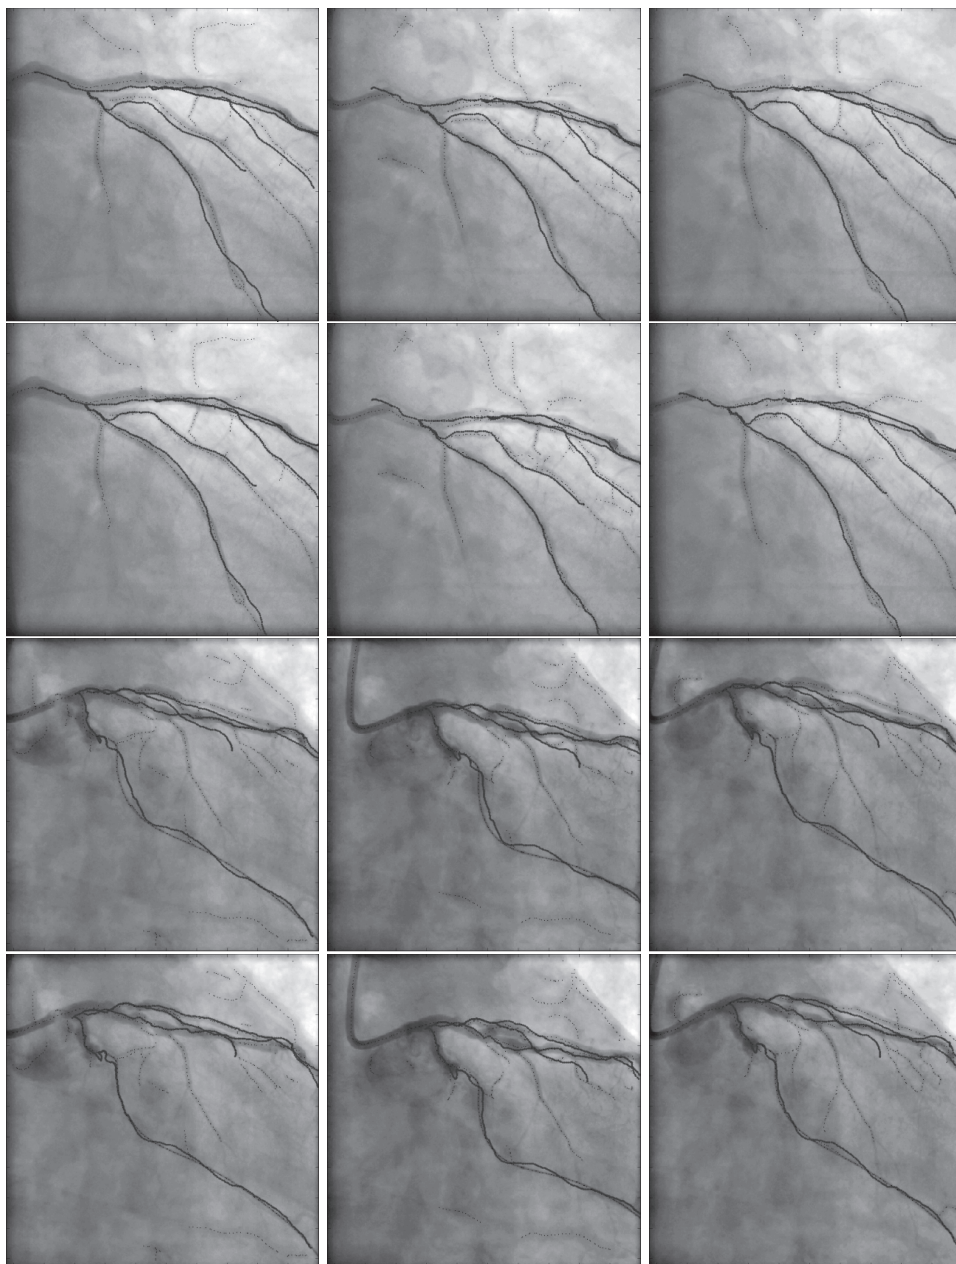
(color version on page 160): 2D+t/3D registrations of 3D vessels (blue) to XA data of two patients. Images are taken at 15%, 50%, and 85% of the cardiac cycle. First and third rows use the 4D CTA based coronary motion, the second and last rows use the SMM. A quadratic respiratory model was used in all cases.
